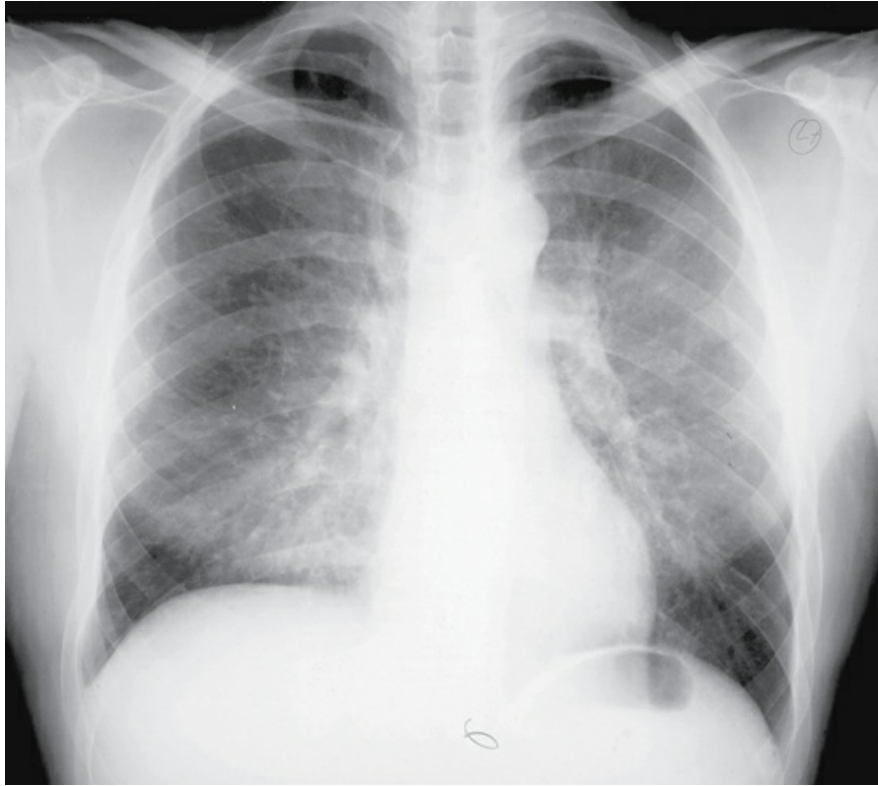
Chest radiograph of a patient with AIDS and pneumonia due to *Pneumocystis jiroveci*. Infiltrates representing the alveolar filling are most prominent at the right base, but also appear in the left midlung field as diffuse haziness.
